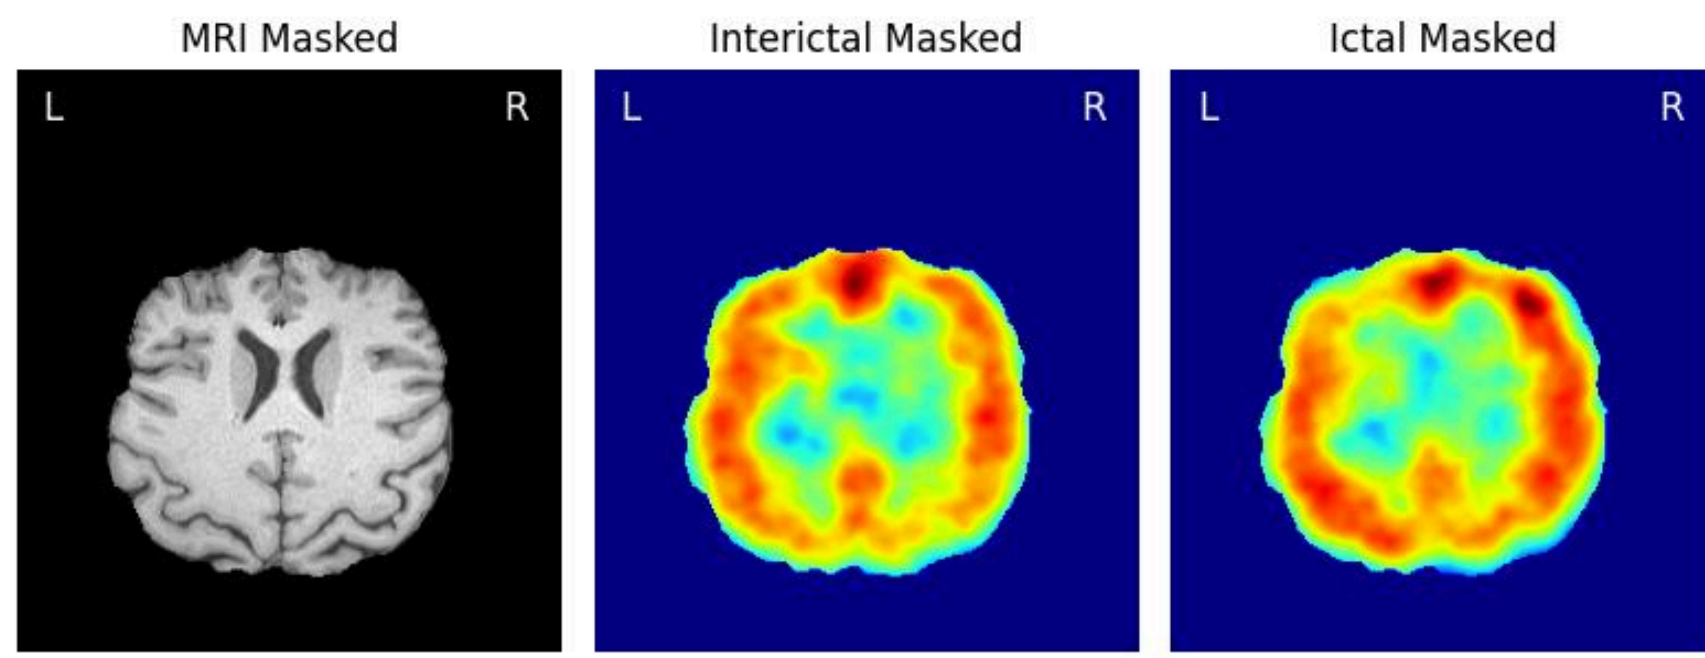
Axial cuts of the MRI, Interictal SPECT, and Ictal SPECT images after masking, all registered to the same spatial reference. Background noise has been reduced to focus on relevant brain regions.
